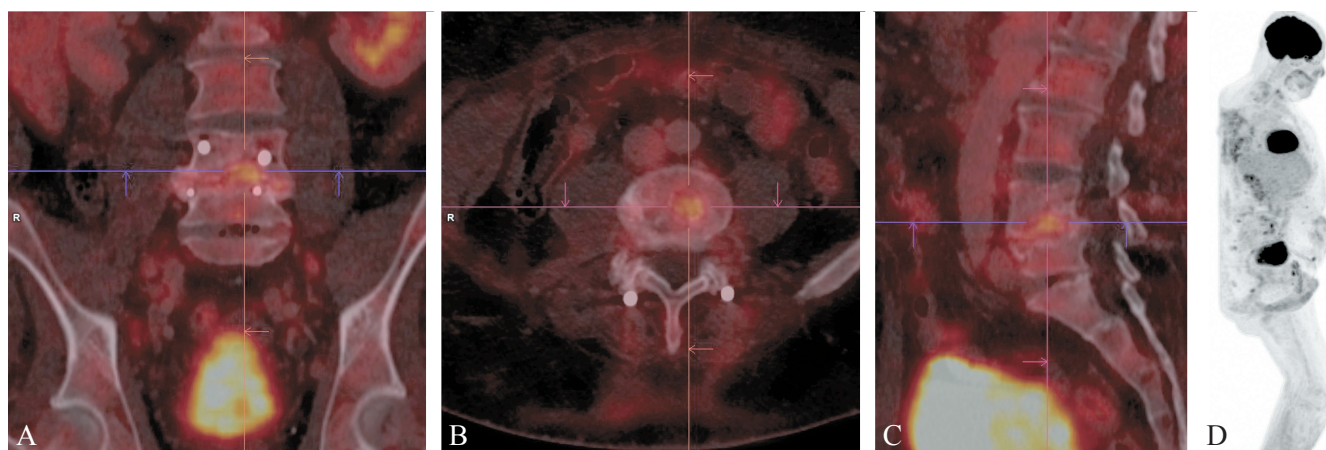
Coronal (A), axial (B) and sagittal (C) fused PET/CT images and MIP image (D) showing re-infection after osteosynthesis L4-L5 due to spondylodiscitis.
